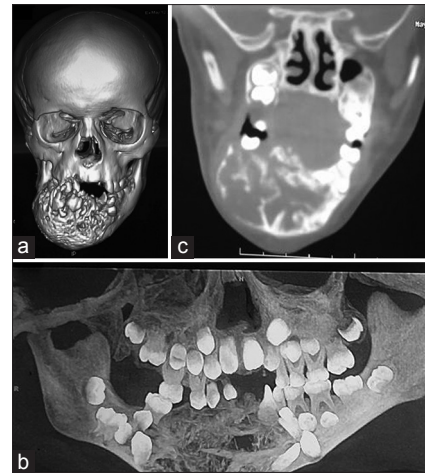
(a) Three dimensional computerized tomography scan of the patient, (b) orthopantomograph, (c) coronal computerized tomography scan
